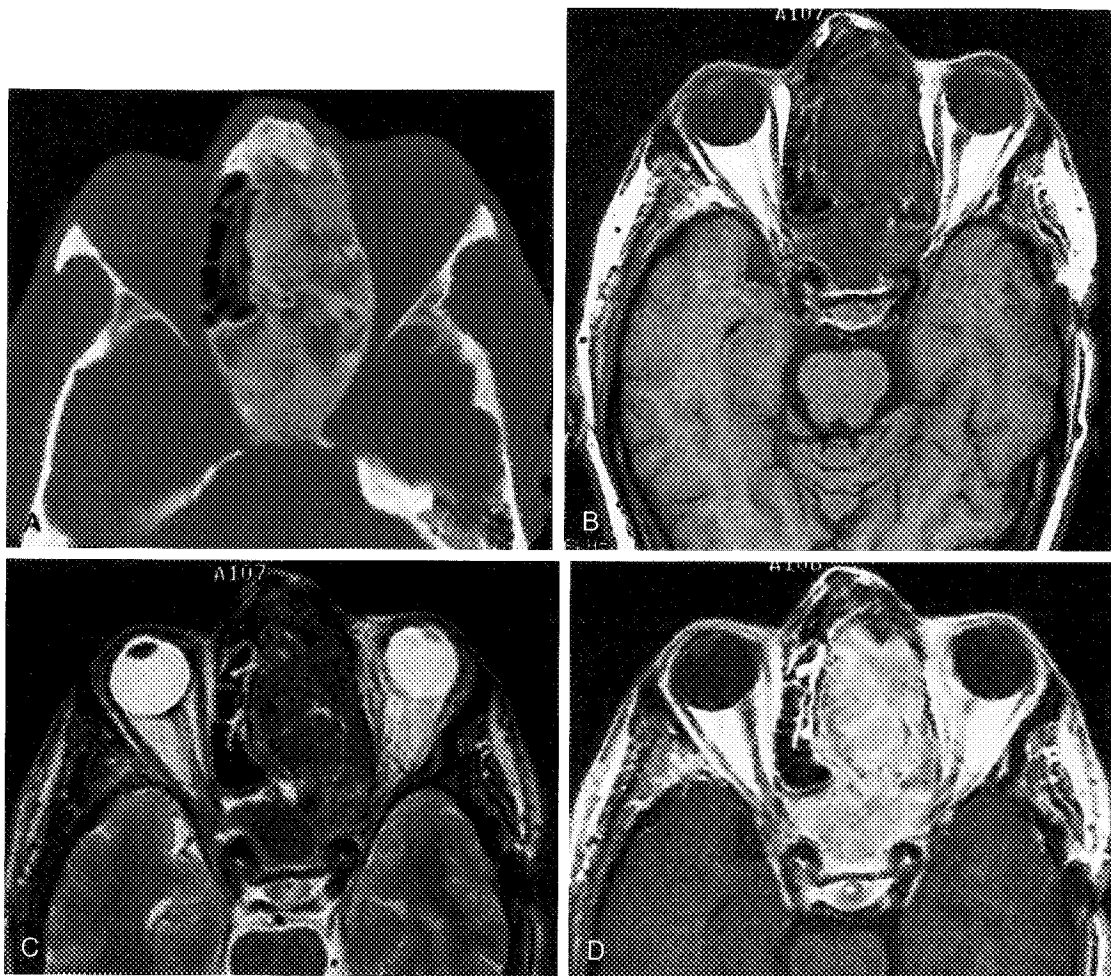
Fibrous dysplasia CT scan (A), T1-weighted MR image (B), T2-weighted MR image (C), and enhanced T1-weighted MR image (D), showing typical CT and MR appearance of fibrous dysplasia. The lesion is hypointense on T1-weighted and markedly hypointense on T2-weighted MR images and shows marked enhancement on post Gd-DTPA MR scan (D). Note that enhancement is more pronounced in areas that are less mineralized.
